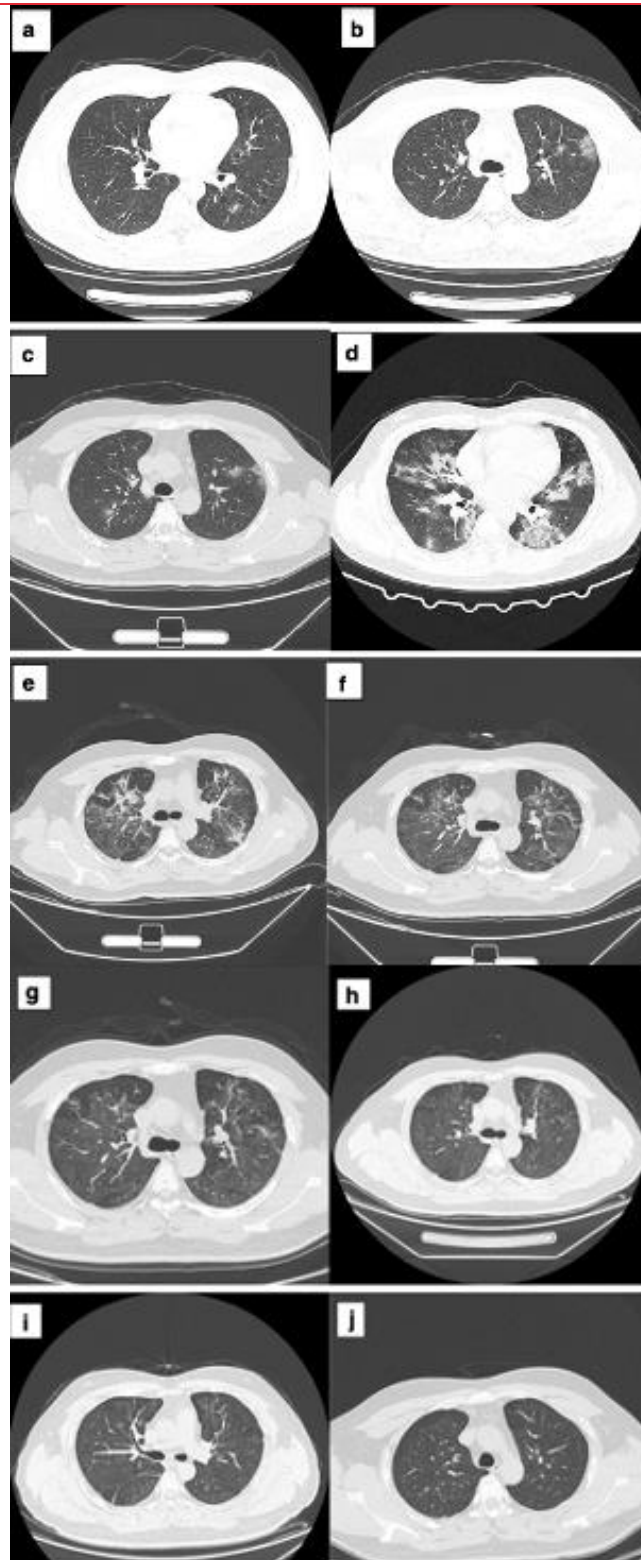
Chest CT of the patient. a Chest CT on January 19. b Chest CT on January 23. c Chest CT on January 25. d Chest CT on January 27. e Chest CT on February 22. f Chest CT on March 1. g Chest CT on March 9. h Chest CT on March 1. i Chest CT on April 17. j Chest CT on May 25.
